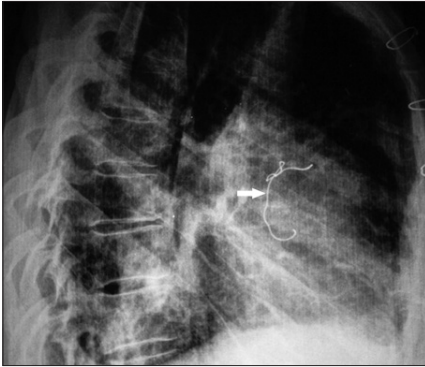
The lateral radiographic projection showed a radiopaque marker confirming a retained sponge.
